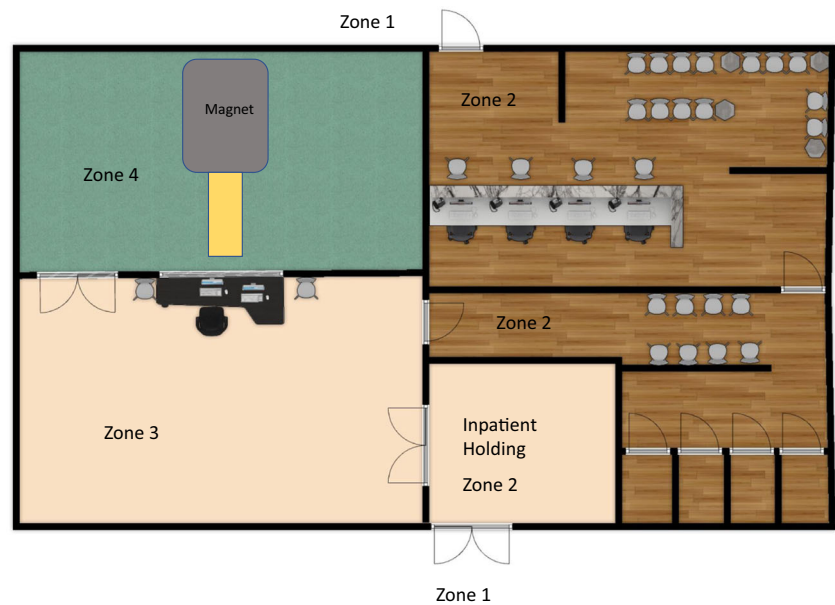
An idealized MRI suite layout. Door between different zones with the exception of the door between zones one and two should be pass card or key controlled to prevent the free movement of people between zones
